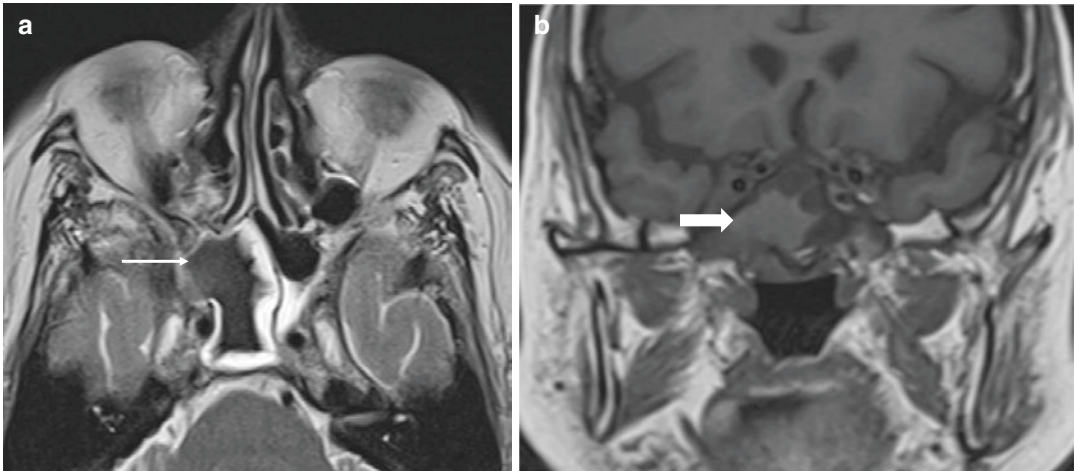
(a) Axial T2 weighted MRI scan showing very low signal in the right sphenoid sinus centrally (thin white arrow), similar to the signal in aerated sinus. (b) Coronal
